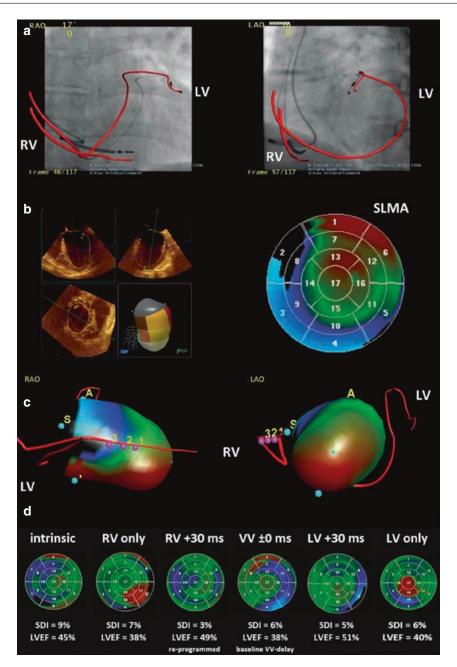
Fusion imaging in cardiac resynchronization therapy. Panel (a): On fluoroscopic rotation scan, the course of the right and left ventricular leads is registered. The right anterior oblique (RAO) and left anterior oblique (LAO) views are shown. Panel (b): Reconstruction of the 3-dimensional (3D) left ventricular (LV) model obtained with transesophageal echocardiography. The polar map with the time to minimum regional volume is provided. Panel (c): The 3D LV model with the time to minimum regional volume for all LV segments is displayed and fused with the angiographic rotation scan data indicating the position of the LV lead relative to the site of latest
